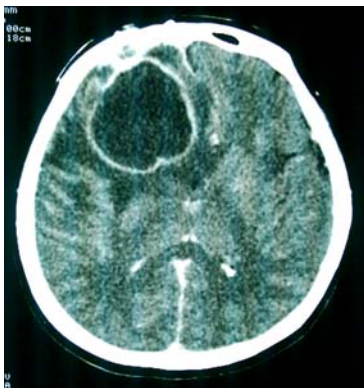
Brain CT with contrast done 1 month post accident and after the reparative surgery revealing a brain abscess with mass effect characterized by a midline shift
